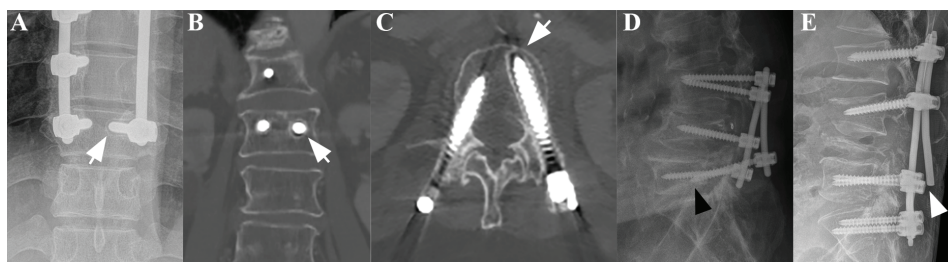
A plain anteroposterior (AP) radiograph (A) and coronal (B) and axial (C) CT scans of a patient subjected to posterior fixation showing radiological signs of screw loosening, indicated by the white arrows. Separately, plain lateral radiographs of a patient subjected to posterior fixation showing radiological signs of screw pull-out ((D), black arrowhead) and rod breakage ((E), white arrowhead).
